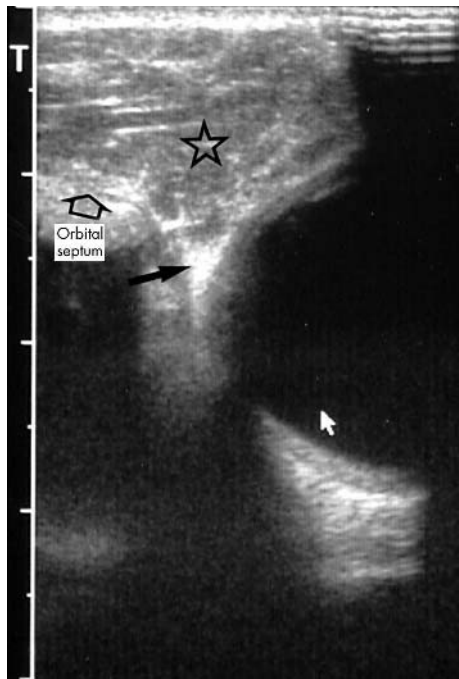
Ultrasound of a mainly preseptal haemangioma which has a finger like projection (black arrow) into the extraconal space of the orbit. The orbital septum is clearly seen (white arrow=vitreous cavity; star=haemangioma).
